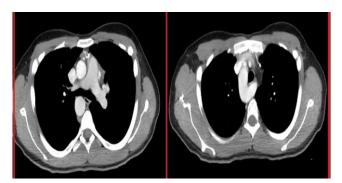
Thoracic computed tomography angiography (CTA) showing a right-sided aortic arch variation and an aberrant subclavian artery
